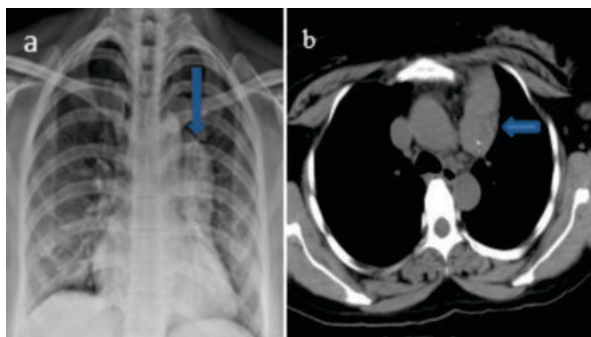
Chest Radiograph (a) shows an anterior mediastinal mass (arrow). Non contrast CT axial sections (b) show soft tissue attenuation mass (arrow) in the anterior mediastinum with calcific focus.
